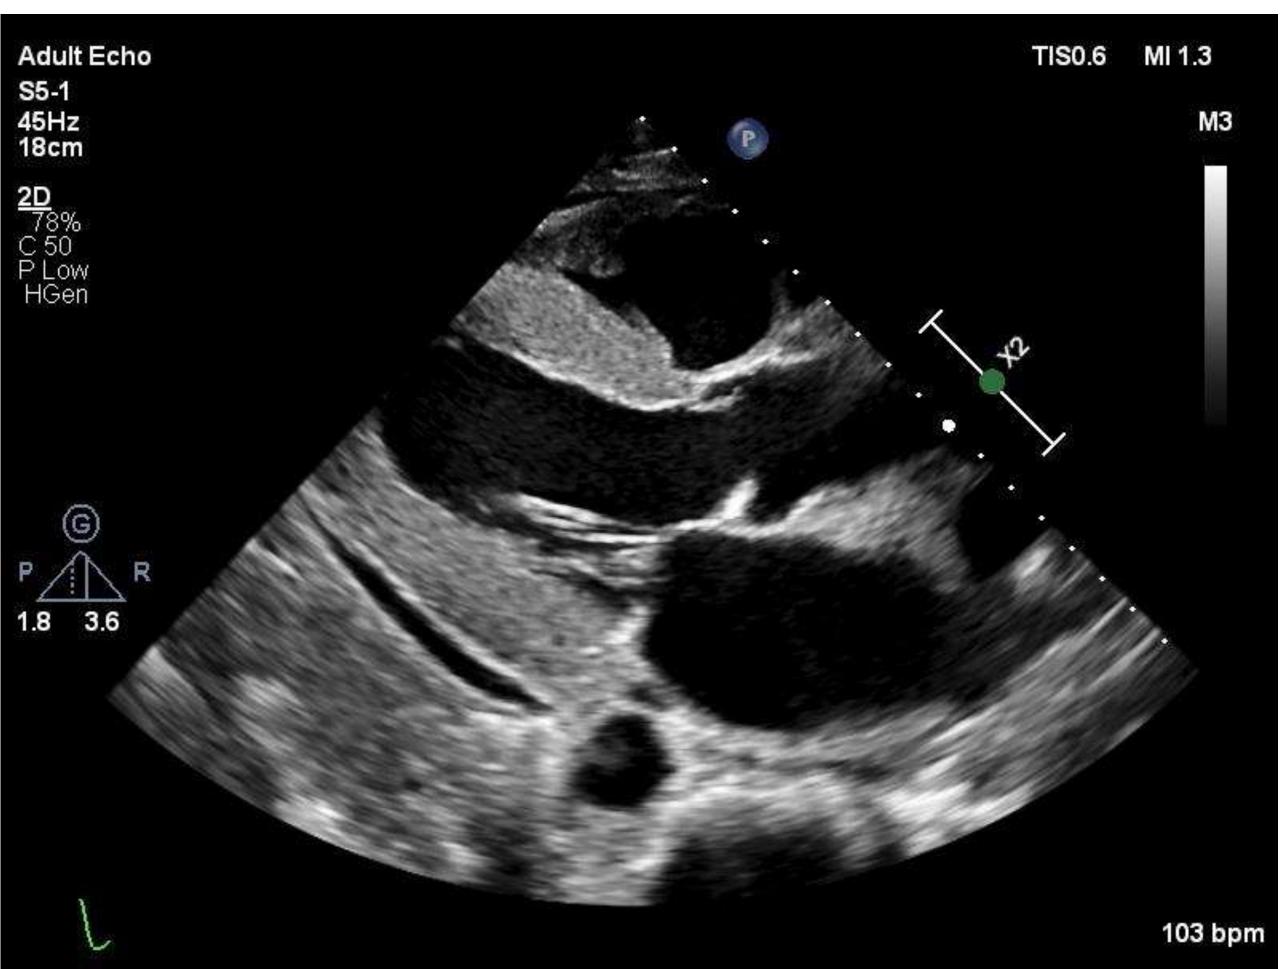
Transthoracic echocardiogram in parasternal long axis demonstrating increased myocardial thickness with speckled pattern.
